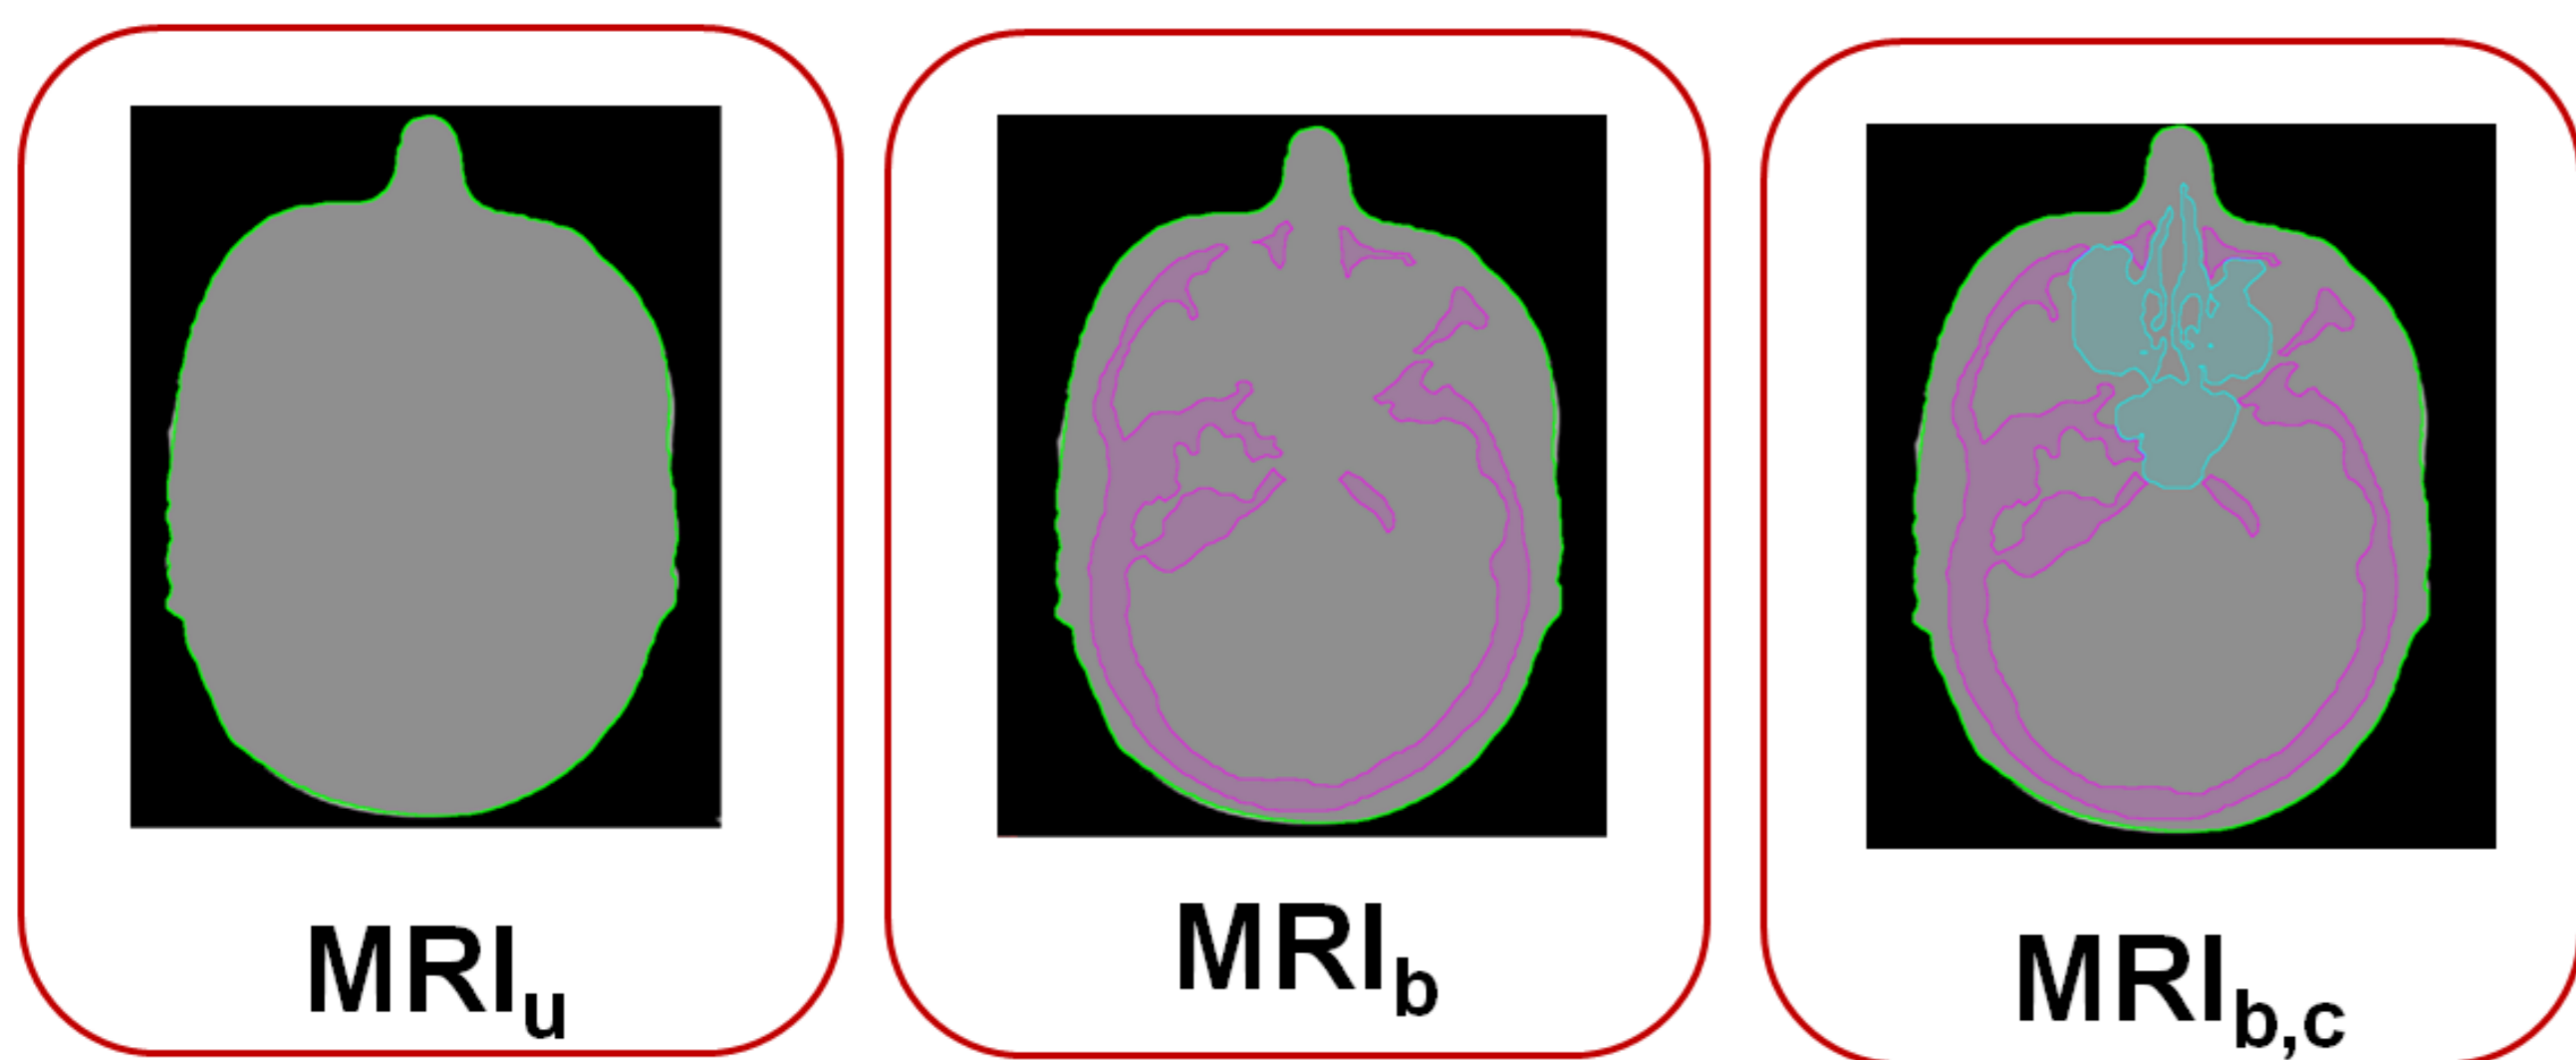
MRI_u: A homogeneous density assigned MRI where the entire body is assigned an HU equal to water. MRI_b: A heterogeneous density assigned MRI where the CT segmented bone is transferred to the MRI and assigned an age dependent HU based on ICRU report 46. For H&N patients, air cavities are also investigated (MRI_{b,c}).
